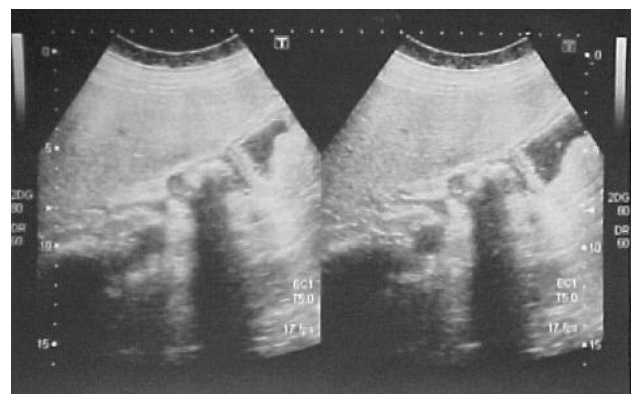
Ultrasound shows echogenic mass lesion with posterior acoustic shadowing.
